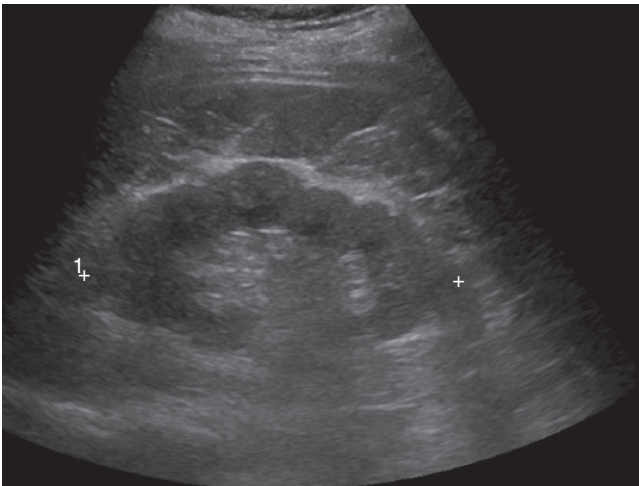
Real-time ultrasound image demonstrates a normal variant of persistent fetal lobulations. The indentations of fetal lobulations on the surface of the kidneys project in-between renal pyramids. This should be carefully differentiated from scarring, which occurs opposite to the renal pyramids.
